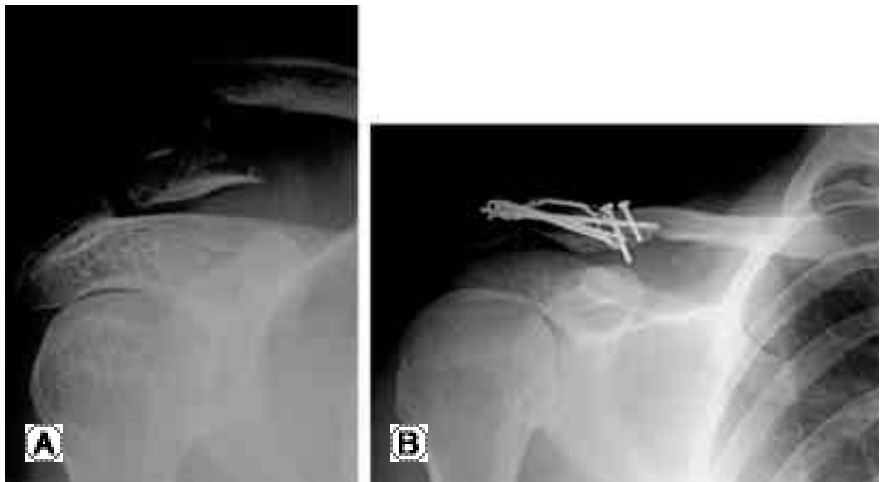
(A)Roentgenogram of 18 years old female showed Neer type Iia clavicle fracture and (B)she was treated by double tension band wiring and miniscrew fixation.
